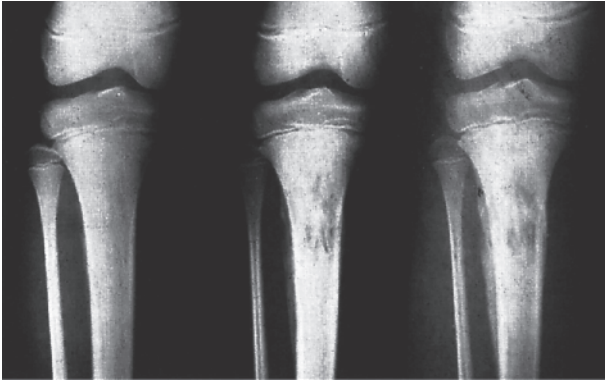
Acute osteomyelitis The first X-ray, 2 days after symptoms began, is normal – it always is; metaphyseal mottling and periosteal changes were not obvious until the second film, taken 14 days later; eventually much of the shaft was involved.
